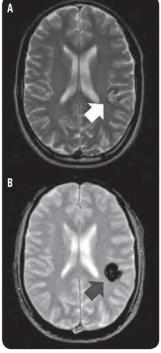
MRI of cavernous malformation
